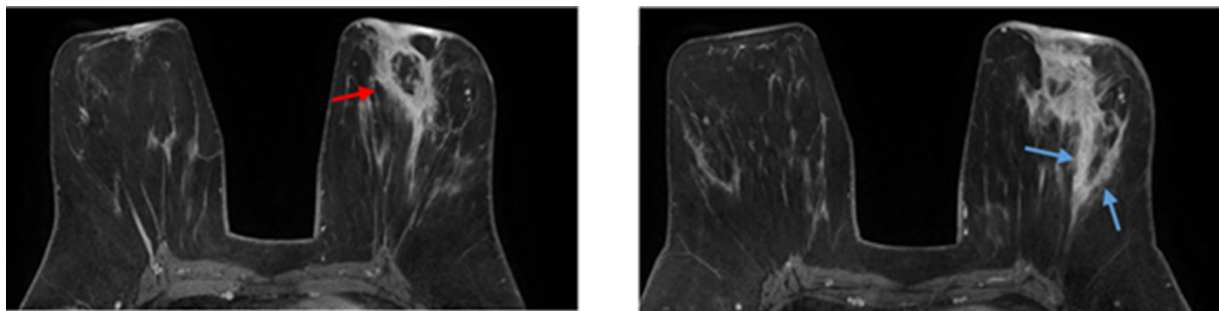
Gadolinium-enhanced T1-weighted fat-saturated images (f,g) show large heterogeneous enhanced retroareolar mass (red arrow) with skin thickening. Linear non-mass enhancement is shown in the outer quadrants' union (blue arrows).
